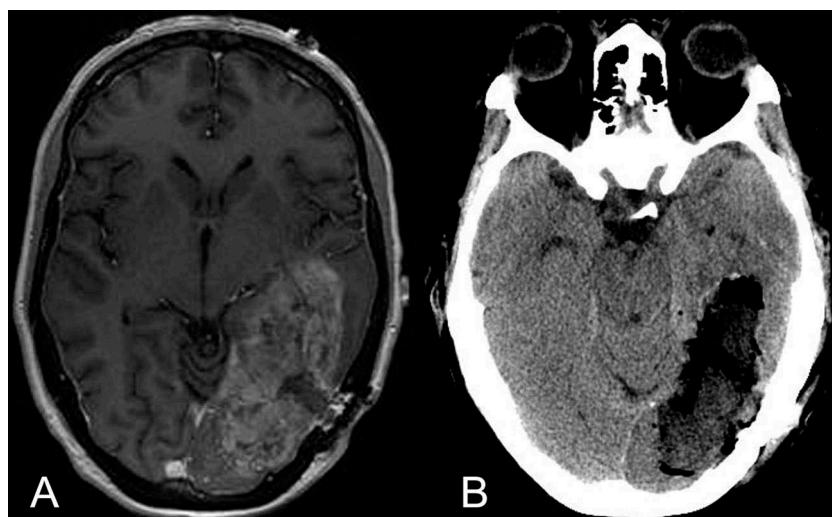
A) Enhanced pre-operative MRI of 54-year-old woman with recurrent glioblastoma. B) CT done 4 hours post-operatively after awake craniotomy and 2 hours prior to discharge from the DSU.
